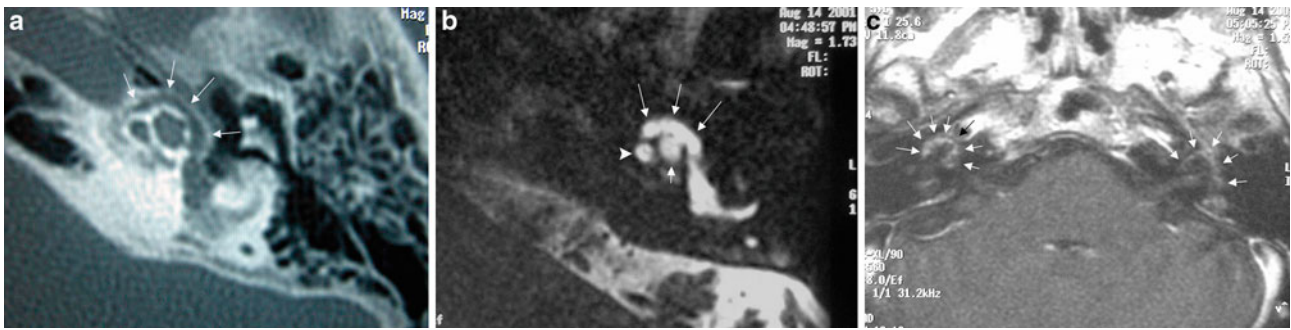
The axial CT image at the level of the middle and apical turns of the left cochlea (a) shows otosclerotic changes around the cochlea: the so-called fourth ring of Valvassori is seen (arrows). The axial 3D FSE T2-weighted image at the same level (b) again demonstrates the fourth ring of Valvassori (large arrows), now seen as a semicircular hyperintensity around the middle (arrowhead) and apical (small
